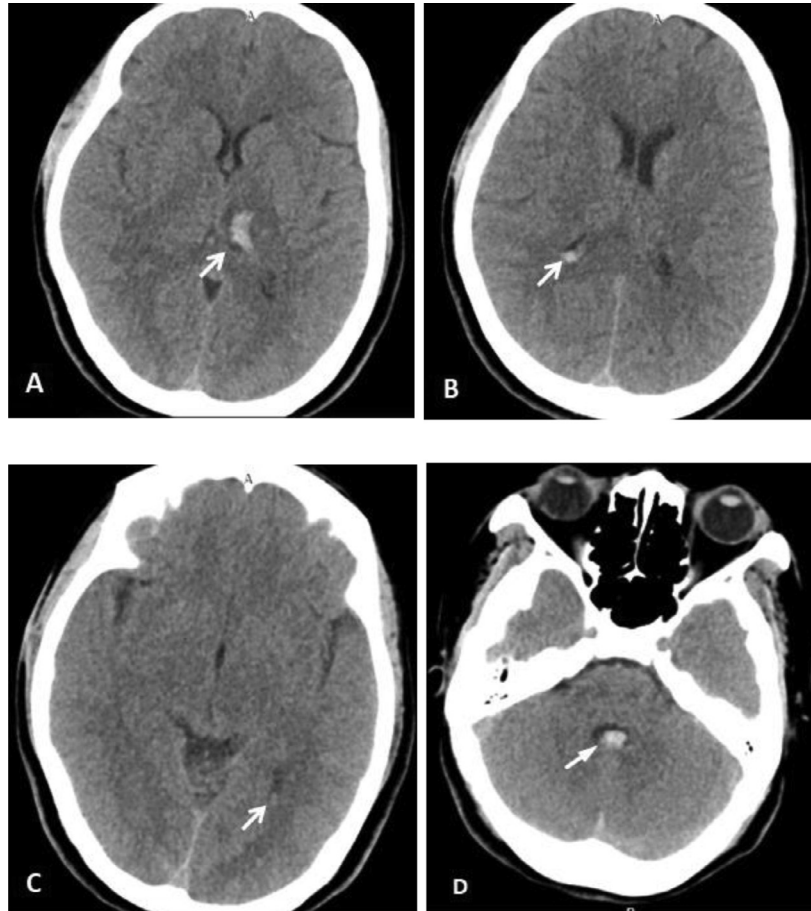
A non-contrast CT scan of brain showing left thalamus hematoma (arrow in figure 1-A), right ventricular occipital horn hematoma (arrow in figure 1-B), horn occipital left ventricle (arrow in figure 1-C), and fourth ventricle (arrow in figure 1-D).
